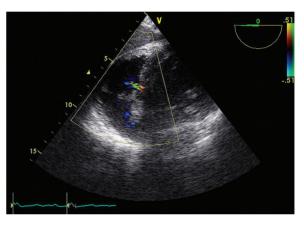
T) Transesophageal echocardiography with congenital ventricular septal defect and CBF and CBV symmetrical cortical filling.
